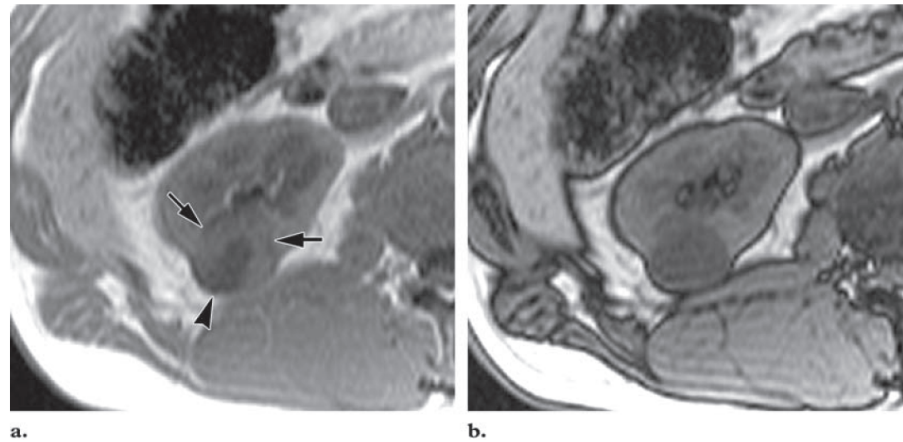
Clear cell RCC (a) Axial in-phase T1-weighted MR image shows a right renal mass with a thick isointense rim (arrows) and hypointense centre (arrowhead) (b) On an axial opposed-phase T1-weighted MR image, the mass appears homogeneous and is hypointense.
